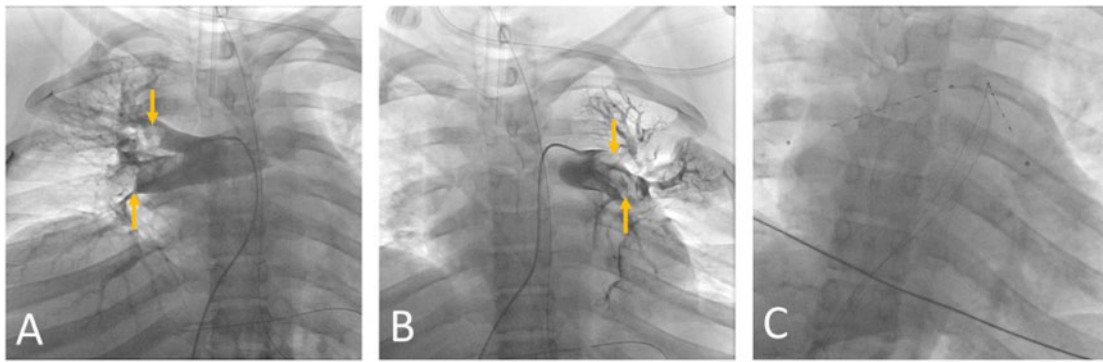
Initial pulmonary angiography and catheter directed thrombolysis. (A) Right pulmonary angiography demonstrating pulmonary emboli (yellow arrows). (B) Left pulmonary angiography demonstrating pulmonary emboli (yellow arrows). (C) Dual ultrasonic thrombolysis catheters in bilateral pulmonary arteries.
